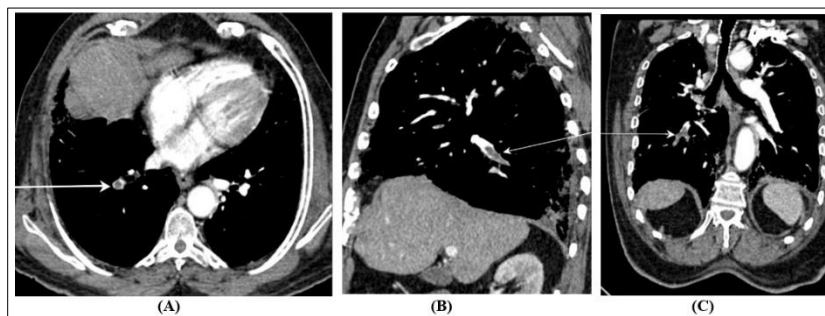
Image (A), (B) and (C), CT Pulmonary angiogram of a 74-year-old male. [A. Axial, B. Sagittal, C. Oblique Coronal images] showing an intraluminal thrombus occupying the common basal trunk branch of the right lower lobe pulmonary artery and the thrombus is also seen extending into the lobar branches. Typical “Polo mint” sign of pulmonary thromboembolism is seen in the axial section.
